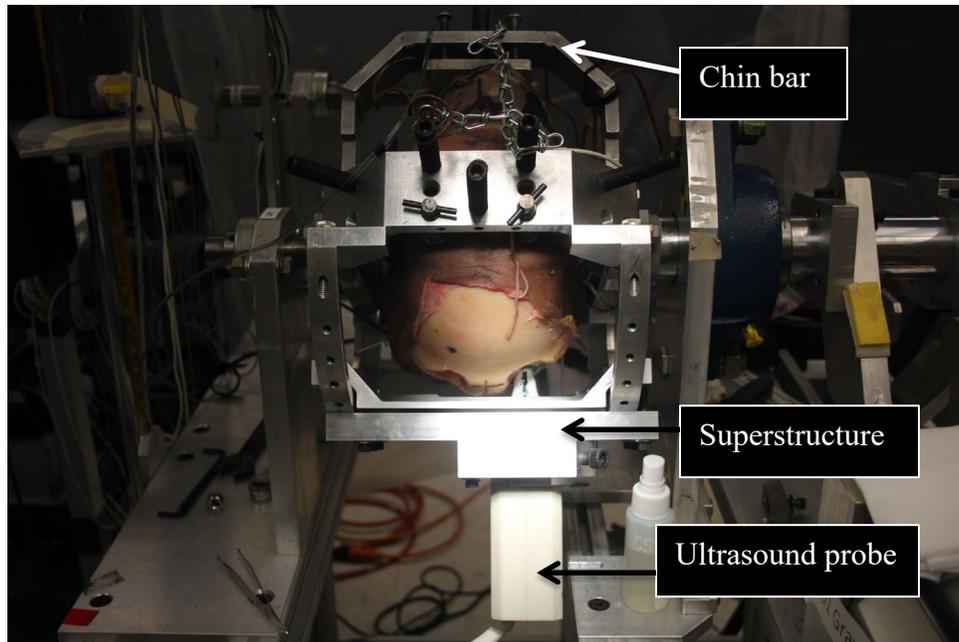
Head in cage installed in rotation fixture with chin bar at top, ultrasound probe mounted in superstructure at bottom
